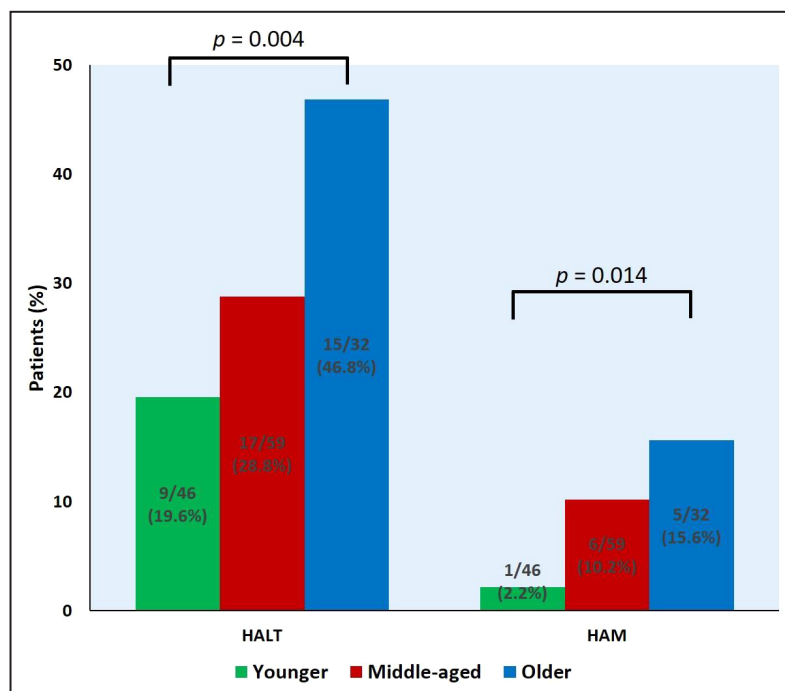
Echocardiographic data postprocedure during the follow-up period.
